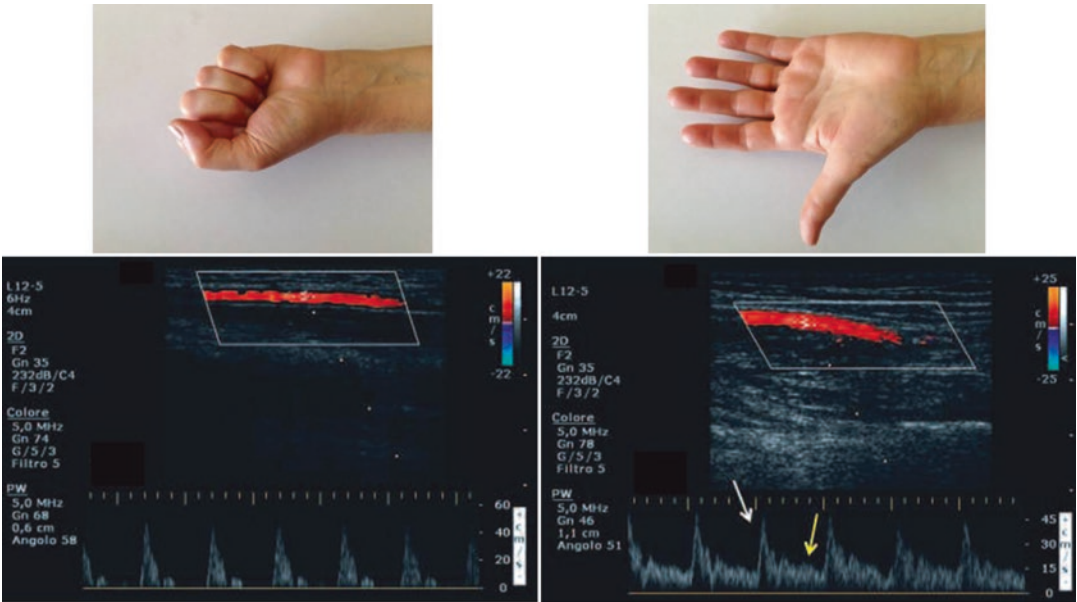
Reactive hyperemia test. *Left*: ischemic phase (*closed fist*) with high-resistance triphasic Doppler spectrum. *Right*: reactive hyperemia (*opened hand*) with low-resistance biphasic Doppler spectrum (*arrows*)
